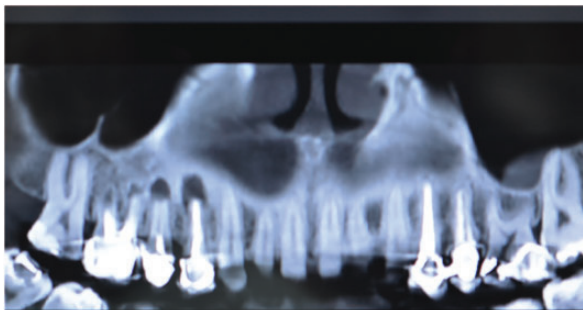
Radiograph of the patient
